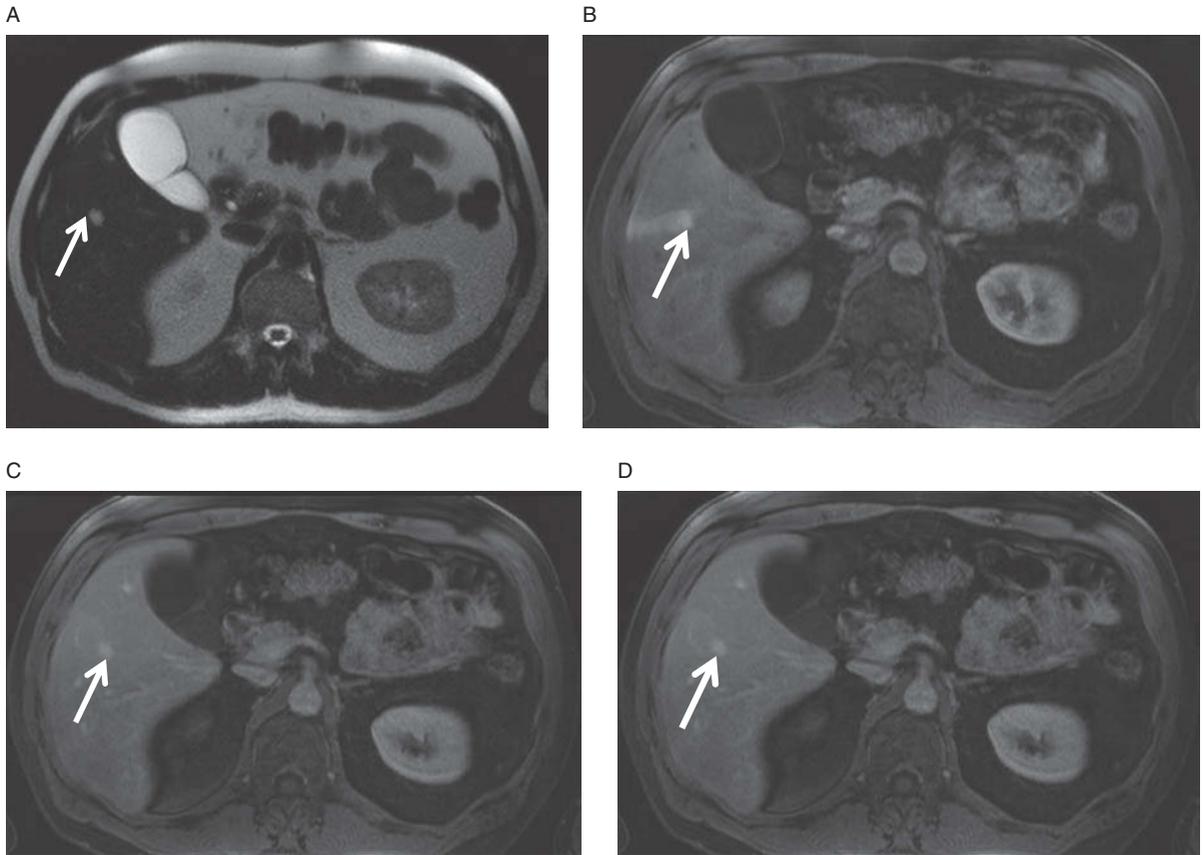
Atypical, flash-filling hemangioma. Axial T2-weighted image (A) demonstrates a very bright lesion within the liver measuring less than 1 cm. Axial, T1-weighted, fat-saturated arterial-phase image (B) demonstrates immediate, homogeneous enhancement of the lesion which follows the enhancement of the blood pool and portal venous (C) and delayed images (D). The vascular changes at the periphery of the lesion (seen best on image B) are common in atypical hemangiomas. Most importantly, the lesion follows blood pool on successive phases.
